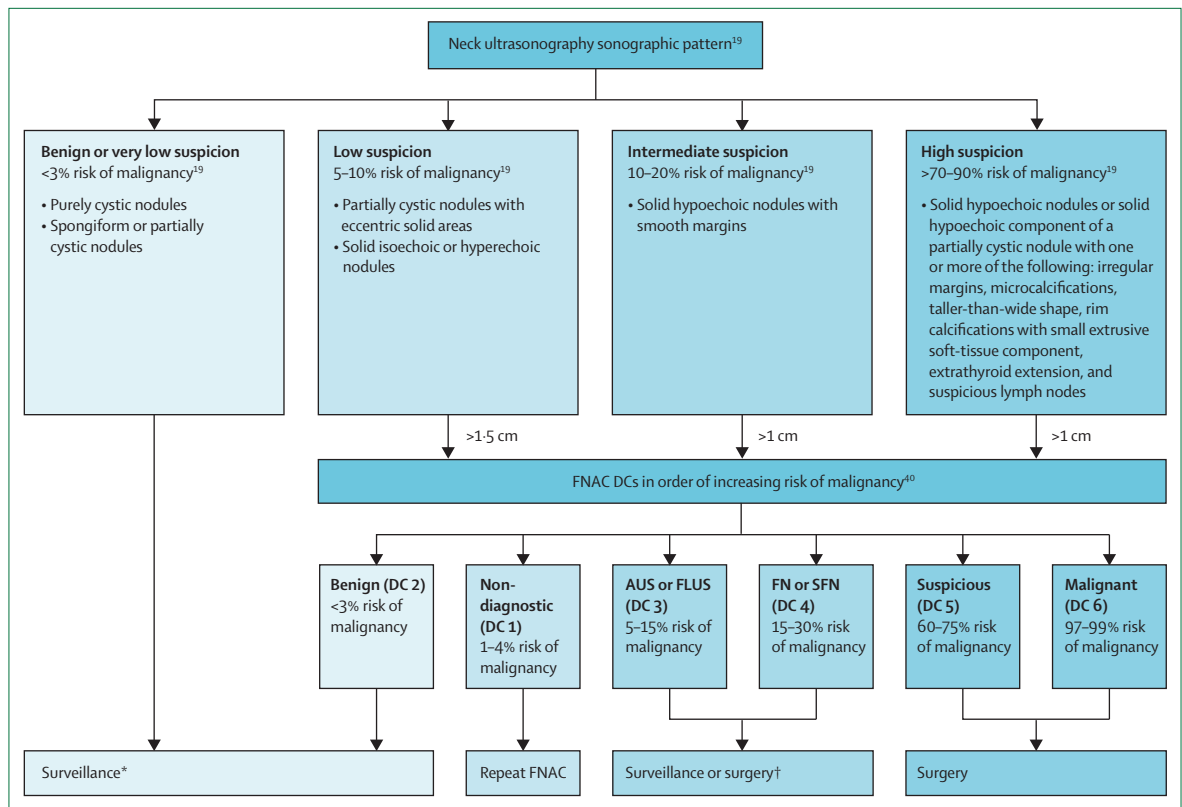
Management of thyroid nodules on the basis of sonographic patterns and cytology diagnostic categories of the Bethesda system
